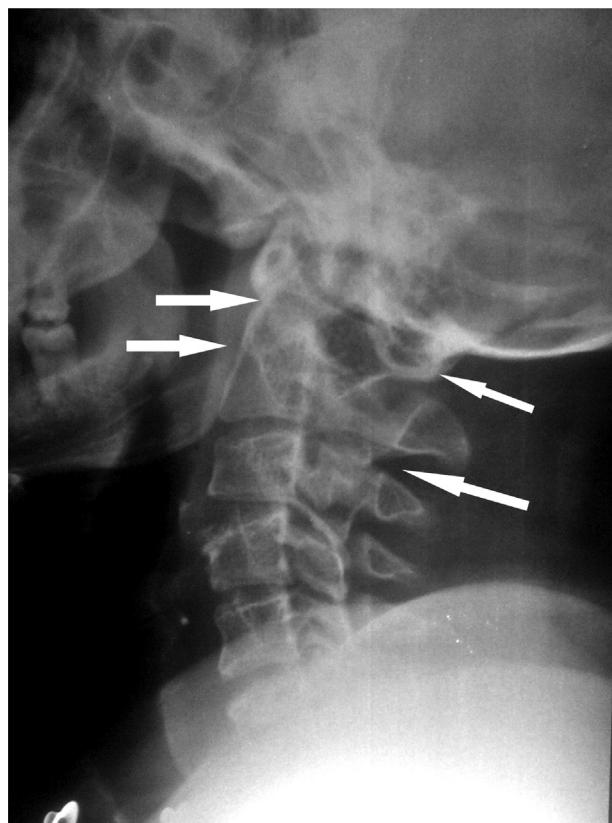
X-ray cervical spine showing almost complete fusion of C1 and C2 and fusion of laminae of C2 and C3 vertebrae (arrows). Please note the reduced space between C1 and skull base and degenerative changes at C3-4 level
